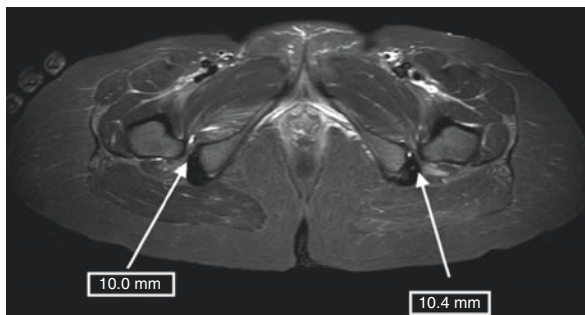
MRI of the pelvis, axial cut, and T2-weighted image without contrast. White arrows represent the restricted ischiofemoral space between femur and ischium. (Reprinted by permission From Springer-Verlag Berlin, Ischiofemoral impingement syndrome: a case report redefining this condition, Hotait, M., Makki, A. & Sawaya, R. *Neurosurg Rev.* (2016) 39: 707. <https://doi.org/10.1007/s10143-016-0766-z>)
